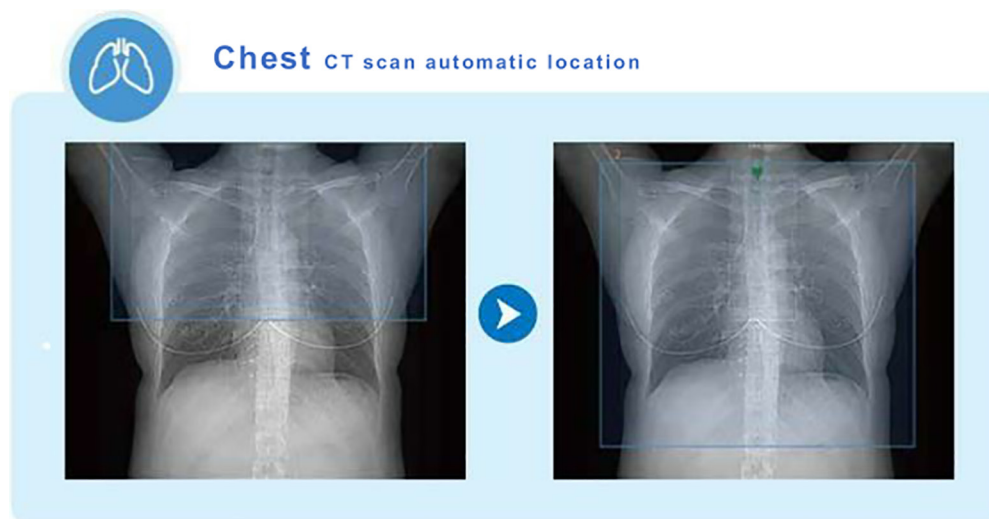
Intelligent chest CT scan location (the blue box in this figure is FOV).
